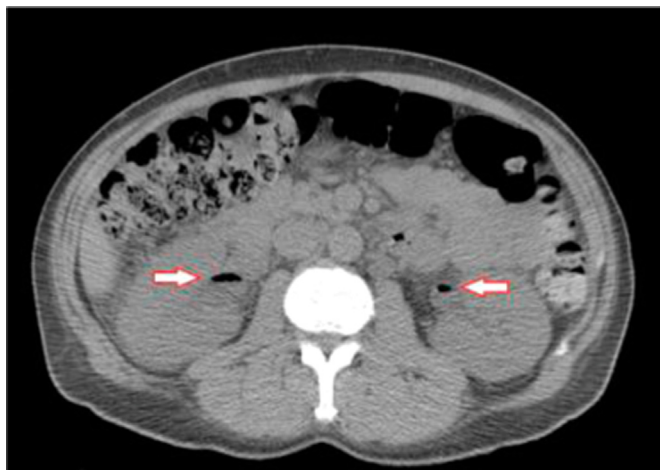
Initial abdominal CT scan with air in the bilateral collecting system.
